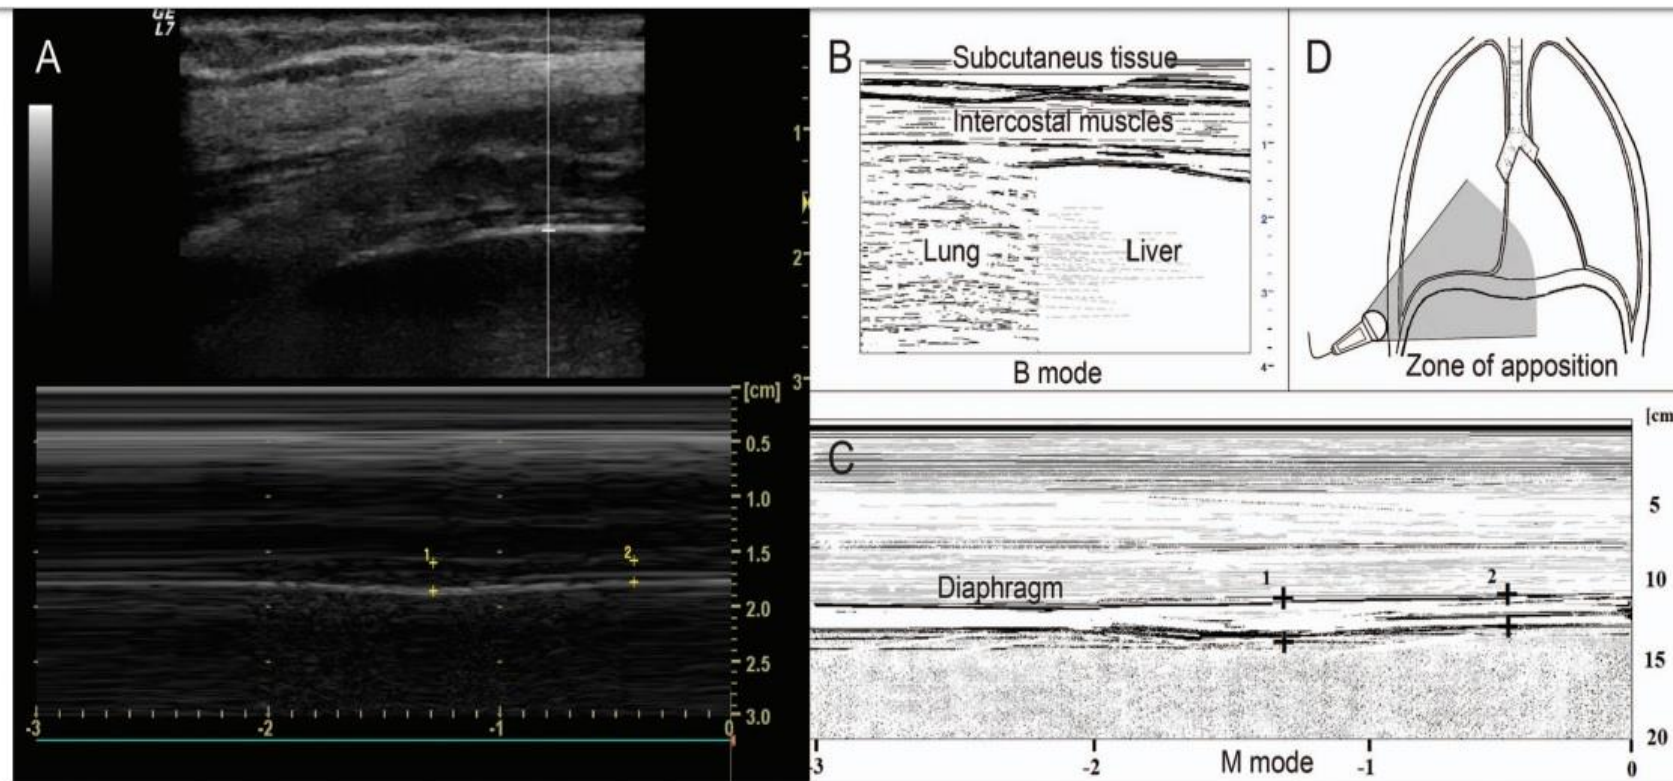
Ultrasonographic assessment of diaphragm thickness. A: Ultrasonographic view of the normal diaphragm in the zone of apposition, with B-mode in the upper part and M-mode in the lower part. B: Anatomical structures that can be identified in B-mode scanning. C: Anatomical structures that can be identified in M-mode scanning. D: Probe placement to explore the diaphragm in the zone of apposition. The distance identified by plus signs 1 in A and C is end-inspiratory thickness, whereas the distance between plus signs 2 in the same panels is the end-expiratory thickness.
